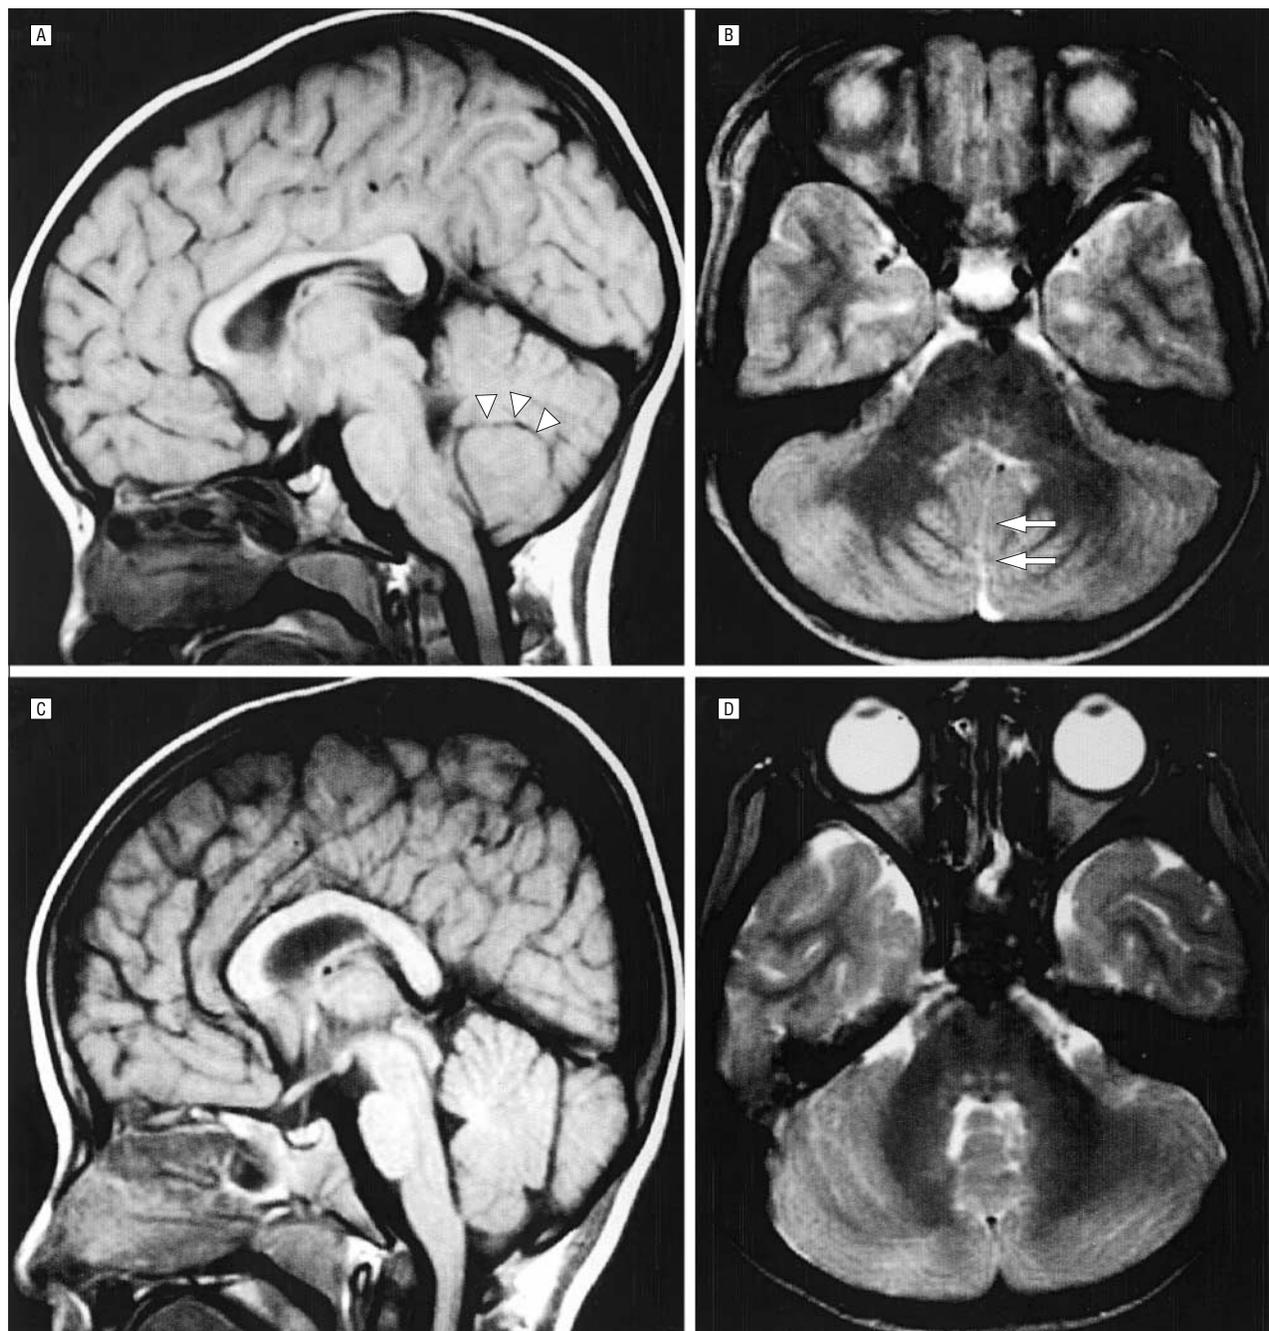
Cerebellar vermal hypoplasia. Magnetic resonance imaging of the brain demonstrates vermal hypoplasia, especially in the inferior portion (arrowheads) (A). The nodulus is absent and the cerebellar tonsils are closely apposed (arrows) (B), compared with the findings in a healthy control subject (C and D).
